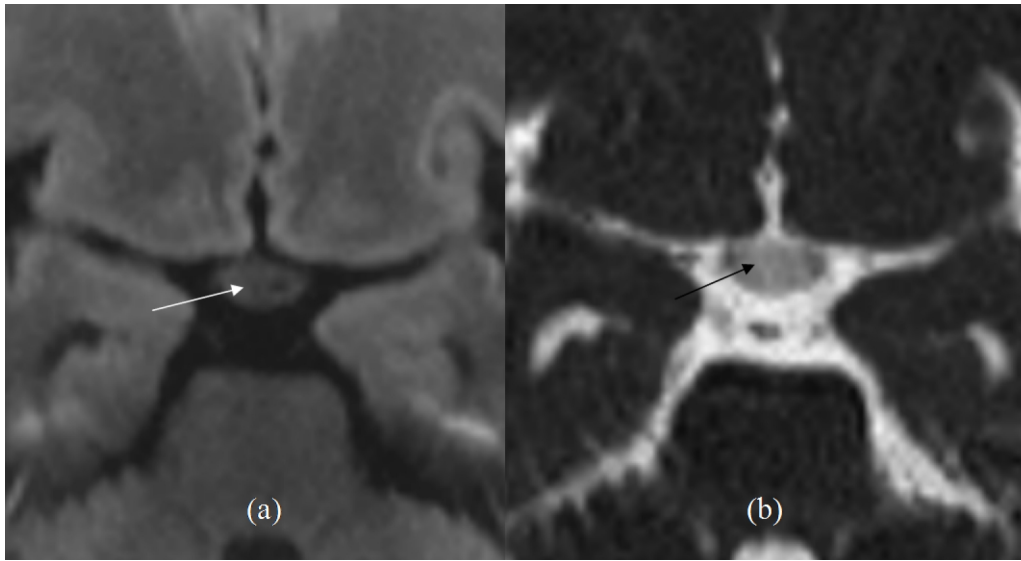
Diffusion-weighted Imaging (a) Axial DWI ($b=1000s/mm^2$) and (b) ADC map showing the epidermoid cyst (arrows). The DWI signal is higher than CSF and similar to white matter. On ADC the signal is intermediate between CSF and white matter.
